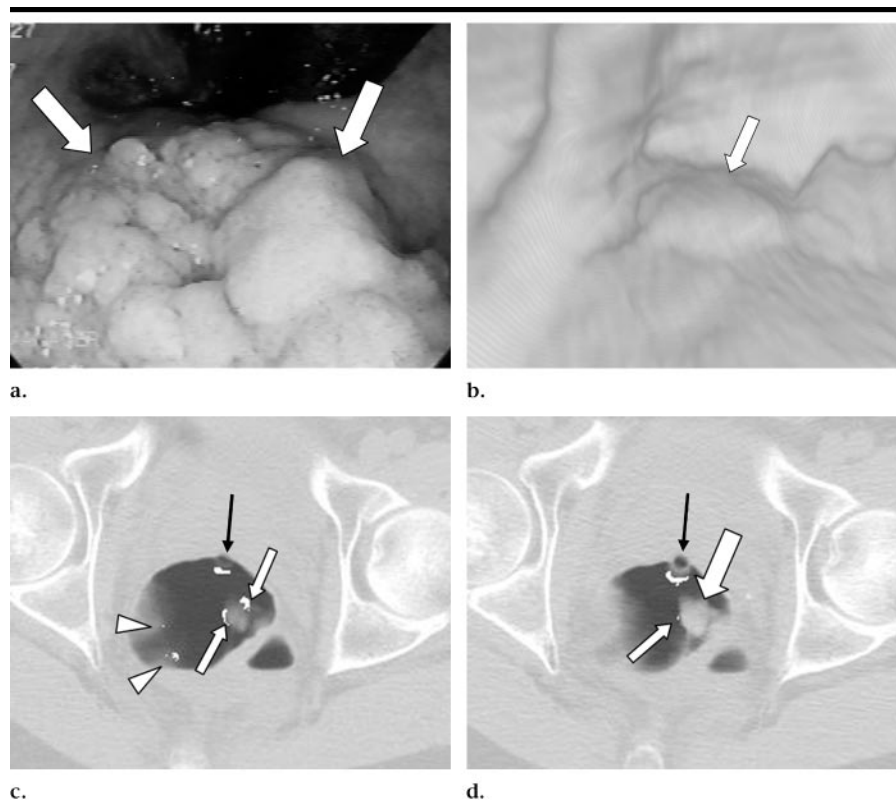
Images of a 3.5-cm villous adenoma, detected with our CAD algorithm but not by either radiologist, in the rectum of a 54-year-old man. (Large white arrows indicate a soft-tissue mass; small white arrows indicate an automated detection mark.) (a) Image from conventional colonoscopy. (b) Perspective endoluminal CT colonographic image. (c, d) Transverse CT colonographic images of two adjacent sections obtained with the patient in the supine position. In d, the automated detection mark (small white line on edge of mass) appears small but is larger on adjacent section (c) of the top of the polyp. The tip of the rectal tube (black arrows) and false-positive locations (arrowheads in c) on rectal folds were also marked by the computer algorithm.
